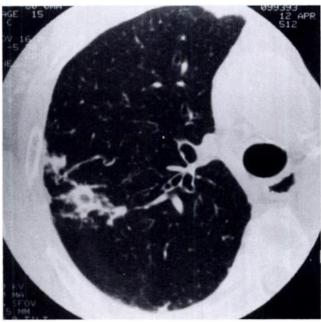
Nonclassical form of disease. CT scan of the right middle lung demonstrates nodular and irregular alveolar hyperattenuation, which is also common in nonclassical NTMB infection.
